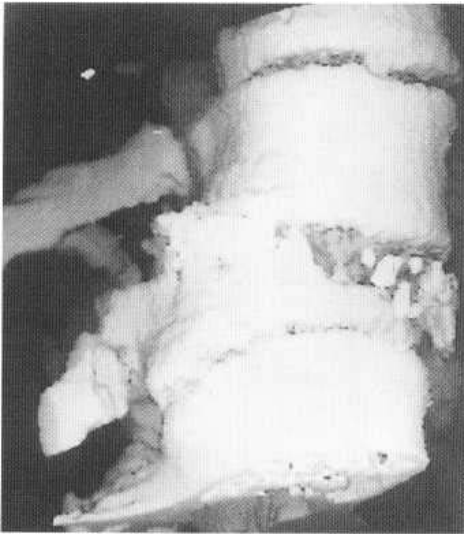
3D CT of the spine. Note crush fracture of the body of L1, with anterior subluxation of T12 on L1.
